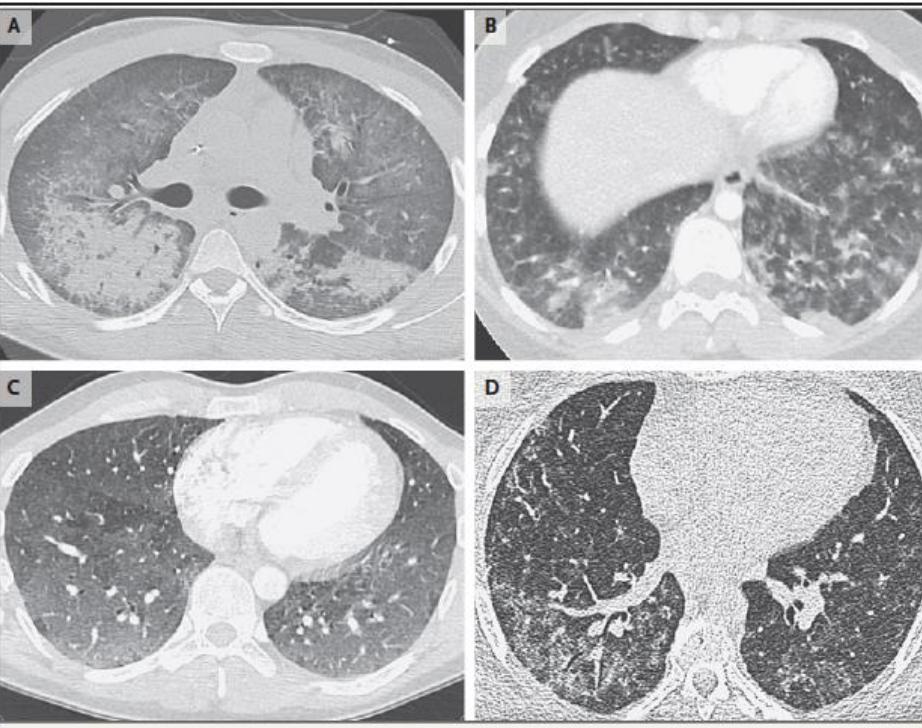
Computed Tomographic Scans of the Chest Obtained from Patients with Vaping-Associated Lung Injury.
